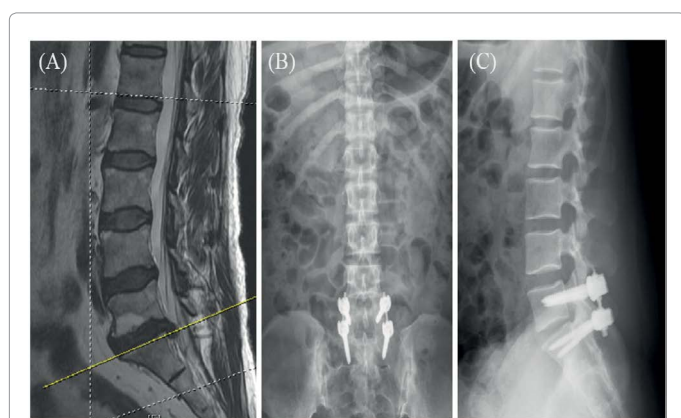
A 40-year-old female diagnosed as L5-S1 disc herniation in MR image (A). Radiographs of 10 months after single-level K-rod dynamic fixation at L5-S1 in anteroposterior (B) and lateral (C) views showed good intervertebral space preservation at the instrumented level without adjacent level problem.
